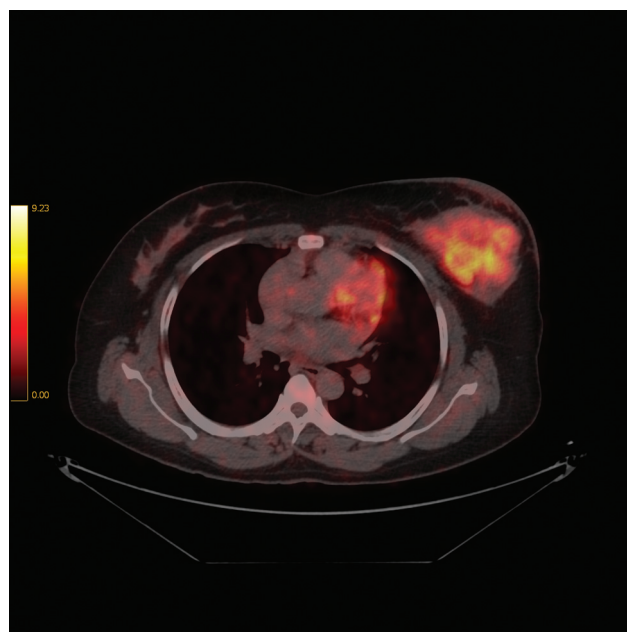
PET CT showing soft tissue mass with necrotic areas in the left breast. CT, computed tomography; PET, positron emission tomography.
